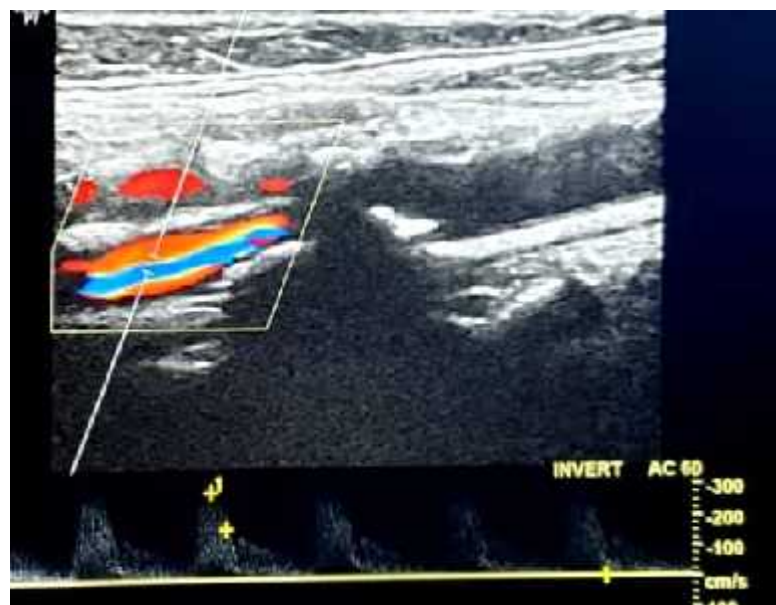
Normal external carotid artery Doppler waveform
